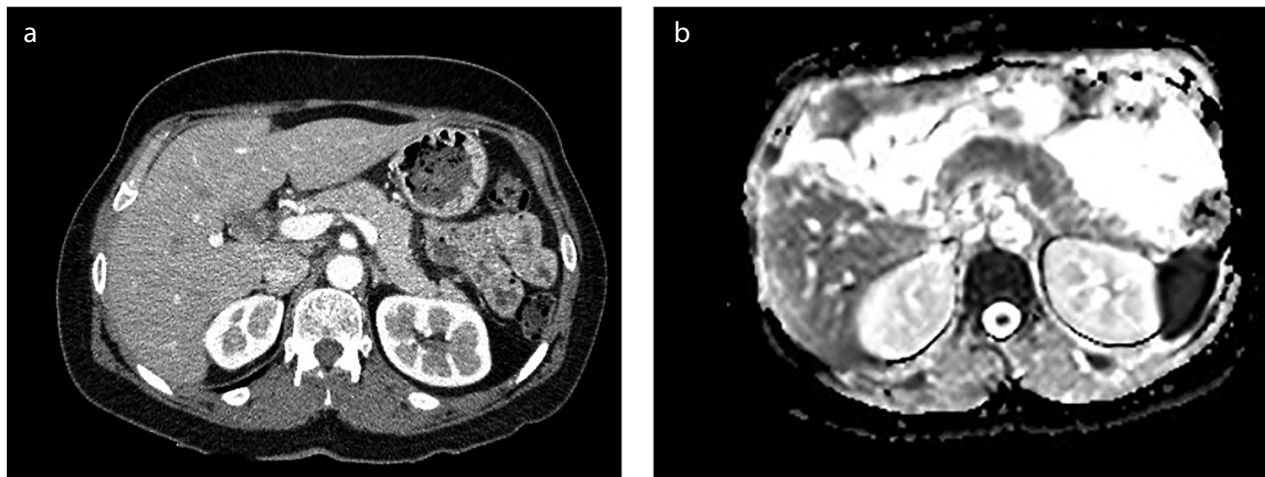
a, b. CT (a) and MRI (b) images of a 40-year-old male patient with necrosis
